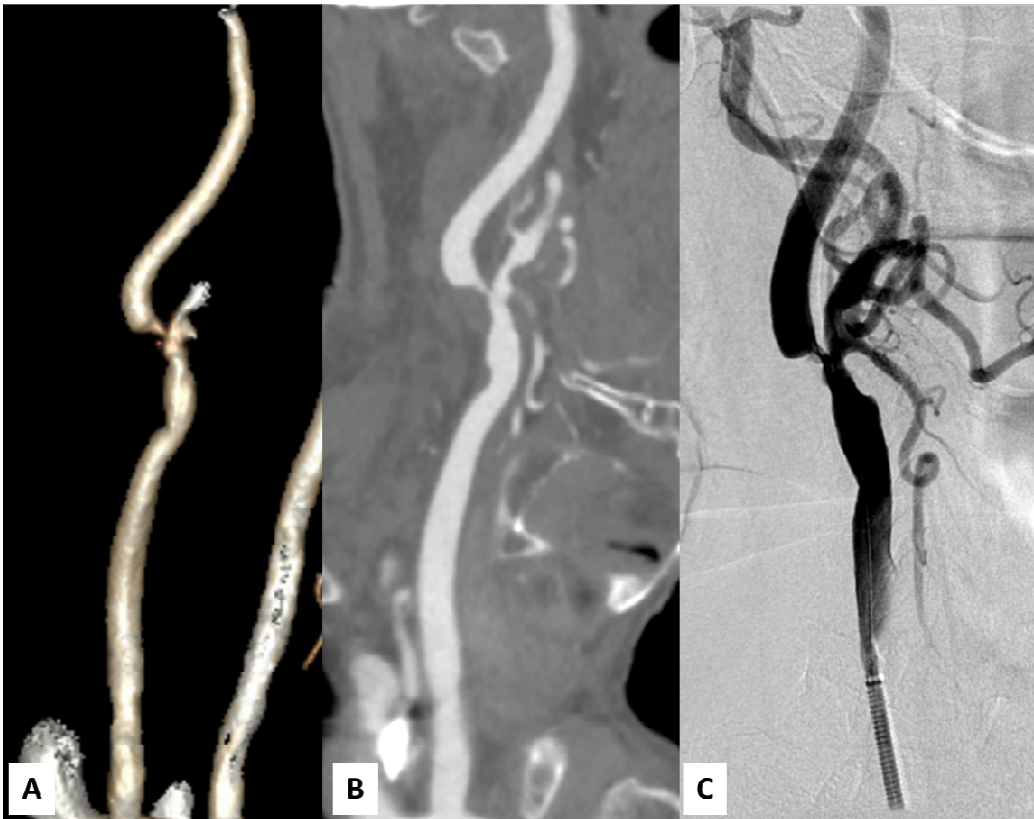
A 80 years old patient with severe stenosis of right ICA due to calcified plaque. Image shows CT multiplanar reconstruction (A), axial image for stenosis area assessment (B) and DSA confirming severe stenosis (C).
